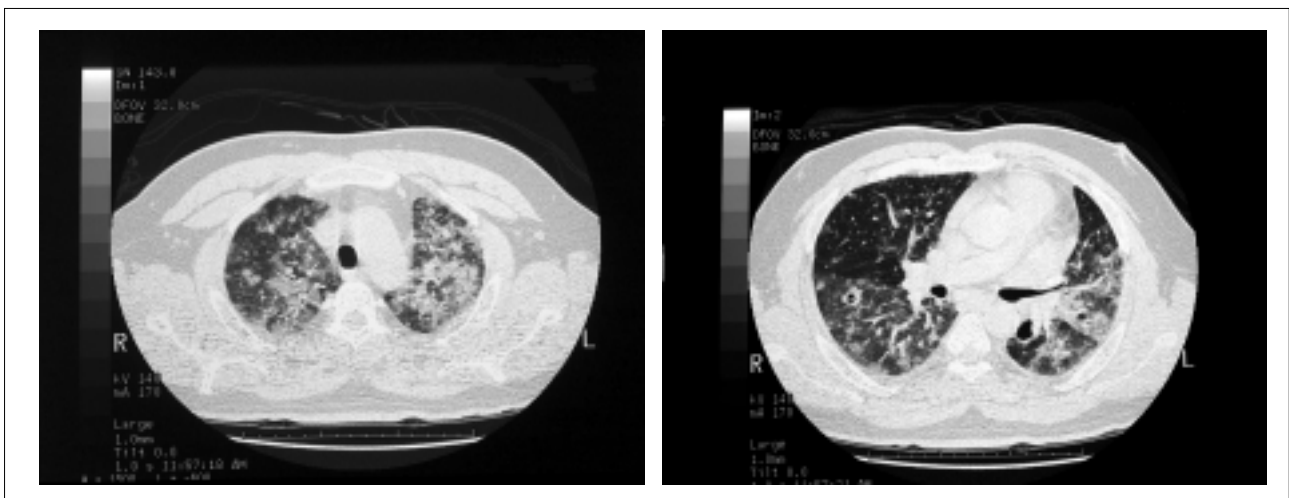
High-resolution CT thorax of Case 1 showing patchy ground glass appearance on both lungs.
